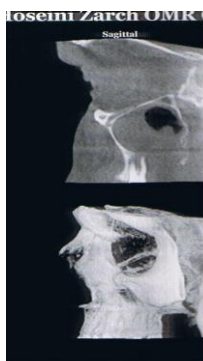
CT scan of left maxillary sinus shows tumoral mass that pushed into the sinus cavity
